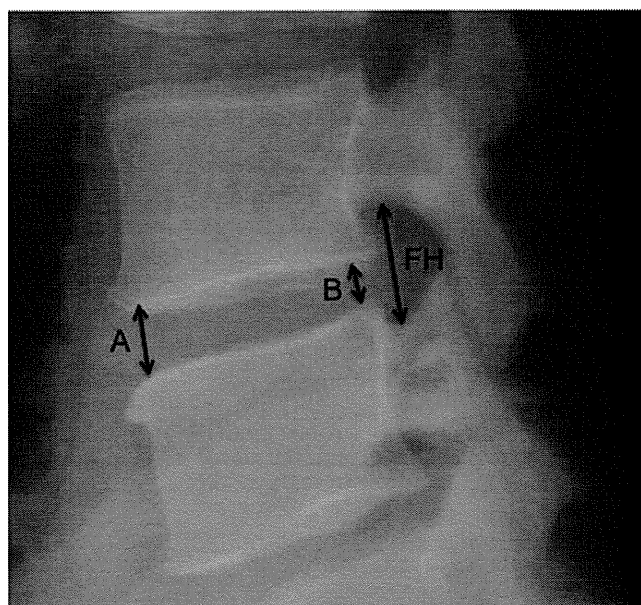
Disc height and foraminal height (FH) were measured using lateral radiographs obtained in the neutral position. Disc height was calculated as the average of the anterior disc height (A) and posterior disc height (B). Foraminal height was measured as the distance between the pedicles.
